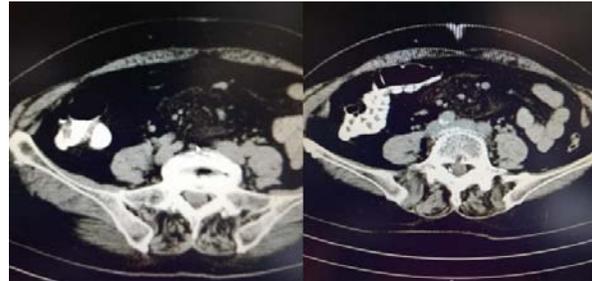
CT scan of the abdomen revealing an 8/4,5 cm tumor which seems to be attached to the ileum.
